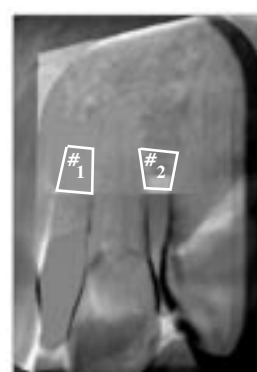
Image of subtraction of “before” and “after” treatment x-ray images with colour filter and marked regions of interest
